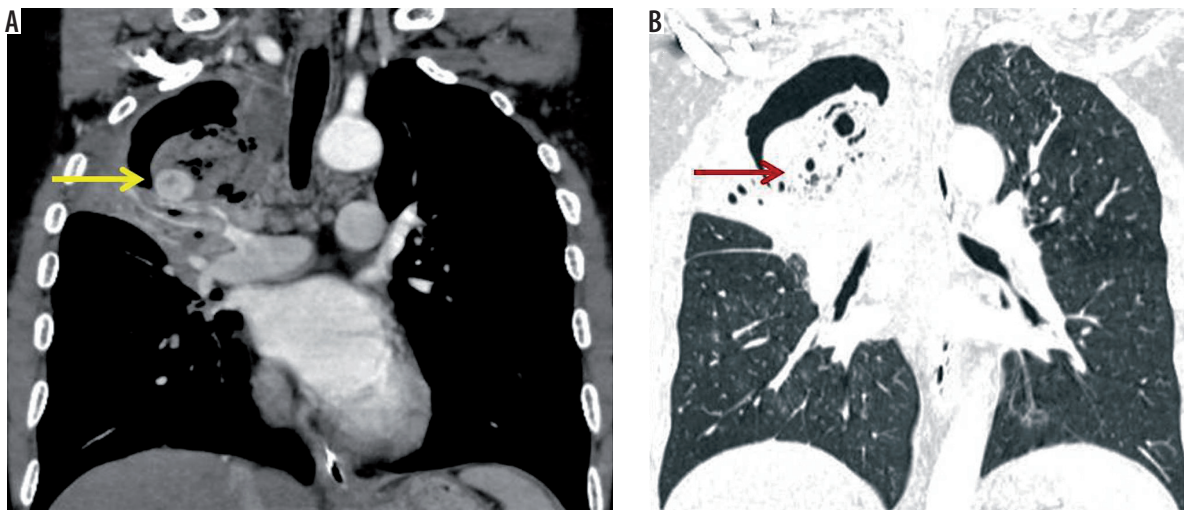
A 51-year-old male patient, previously treated for pulmonary tuberculosis, presented to the emergency services with chronic cough with multiple episodes of streaky haemoptysis followed by one episode of severe haemoptysis. A) Coronal post-contrast computed tomography image mediastinal window shows a large cavity in the right upper lobe with collapse of the right lung. A Rasmussen aneurysm (yellow arrow) is noted along the inferior wall of the cavity. Air crescent sign is seen in the cavity, which is also visible on (B) coronal lung window image (red arrow). This appearance may be seen in aspergilloma or a haematoma in the cavity in the presence of Rasmussen's aneurysm
